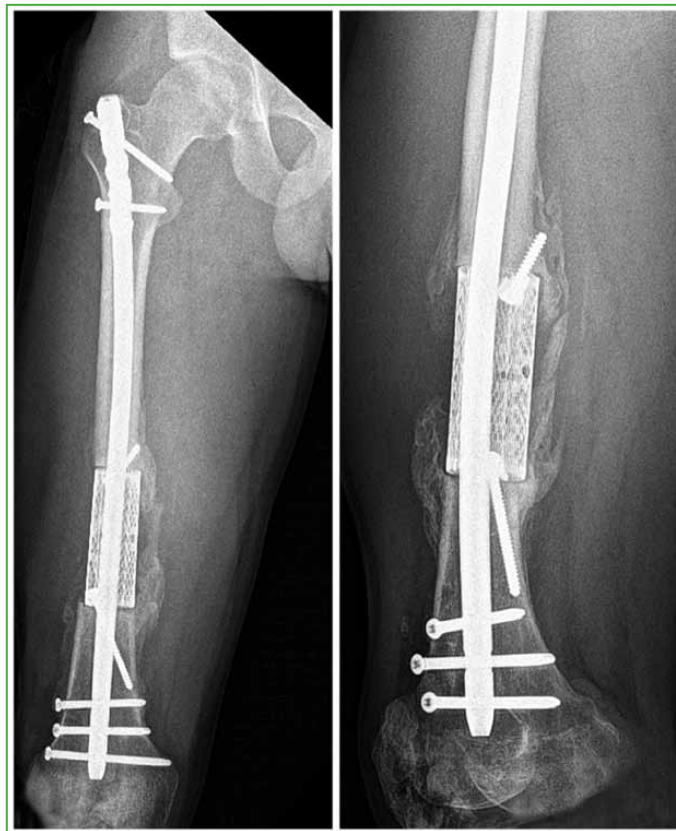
Anteroposterior and oblique radiographs of the entire right femur, two years after surgery. Bone formation encircling the scaffold is observed.
